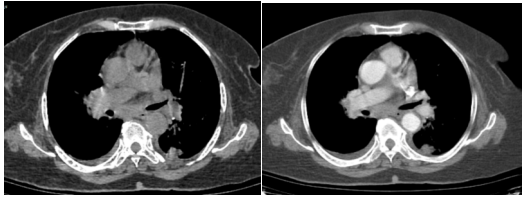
Computed Tomography of a 42-Year-Old Man Presenting With fever and Cough. Plain CT scan shows a round mass in the left lung. Enhanced CT scan shows slight enhancement in the mass which was verified to be a case of pulmonary TB.
